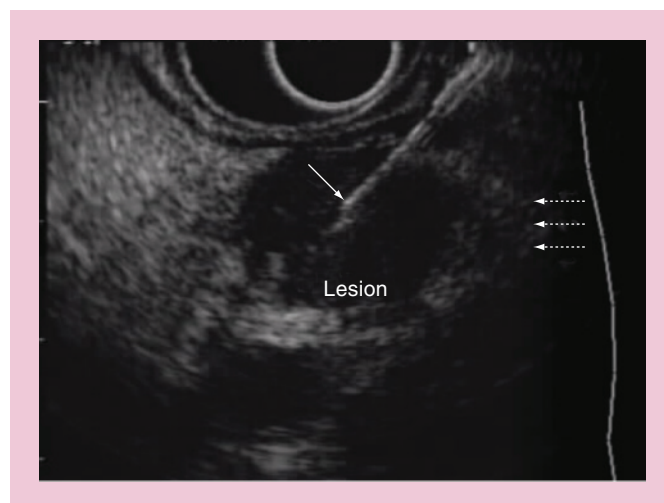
Endoscopic ultrasound image showing fine-needle aspiration biopsy under endoscopic ultrasound guidance using a linear echoendoscope.
